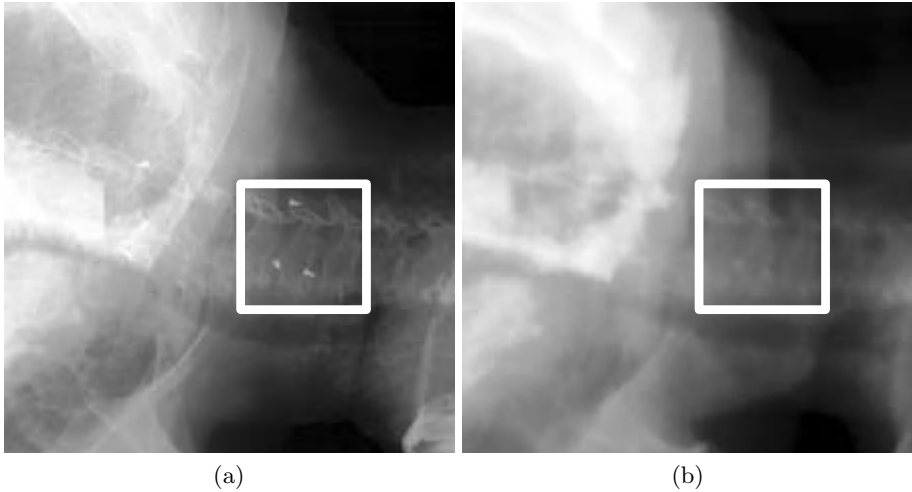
(a) Example x-ray projection image. A box delineates a region of interest (ROI). Three bone-implanted fiducial markers can be seen in the ROI. (b) A DRR (synthetic projection image) generated from a registered (the correct position and orientation have already been calculated) CT image of the same patient using the camera geometry of the x-ray imaging system used to create the image in (a).
